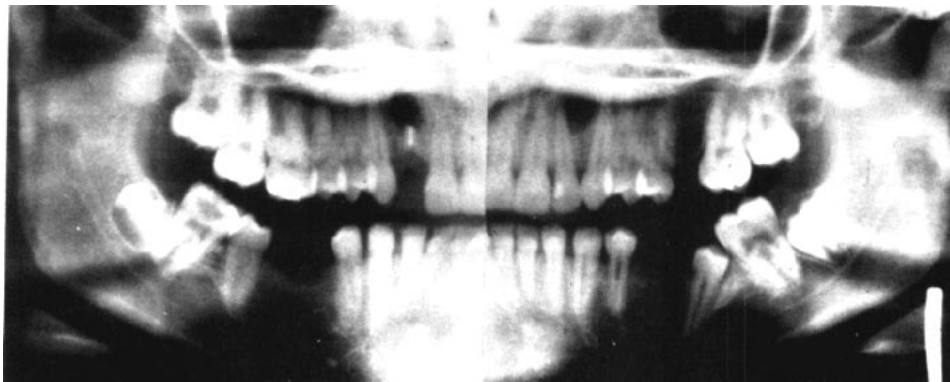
Panoramic radiograph showing bilateral distally positioned mandibular second bicuspid.
